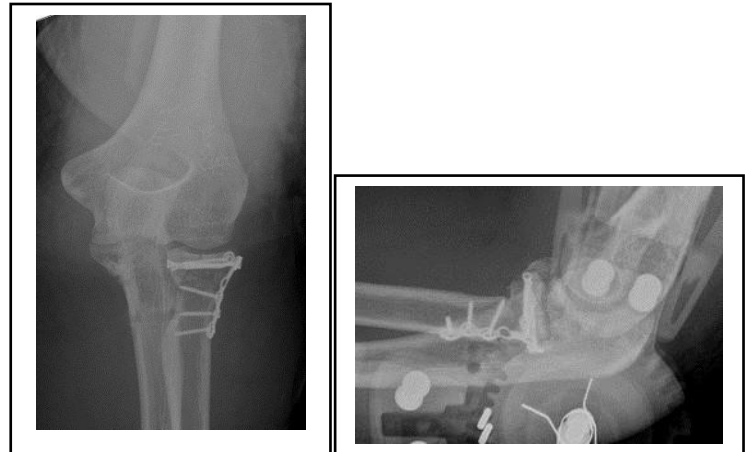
left elbow xray AP view post operative
